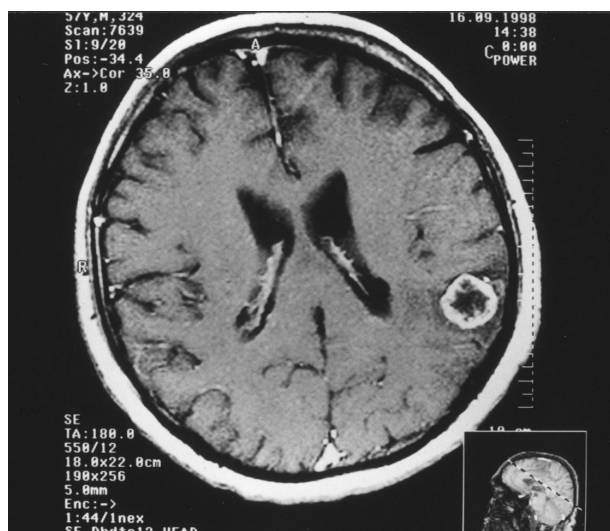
Cystic focal lesion situated in left parietotemporal area. Intense margin enhancement after gadolinium injection, with hypointense area (necrosis), Fig. 3a. Hyperechogenic border around the tumour with hypoechogenic inner area in intraoperative USG examination. Oedema around the lesion, with compression of the left lateral ventricle in MRI
